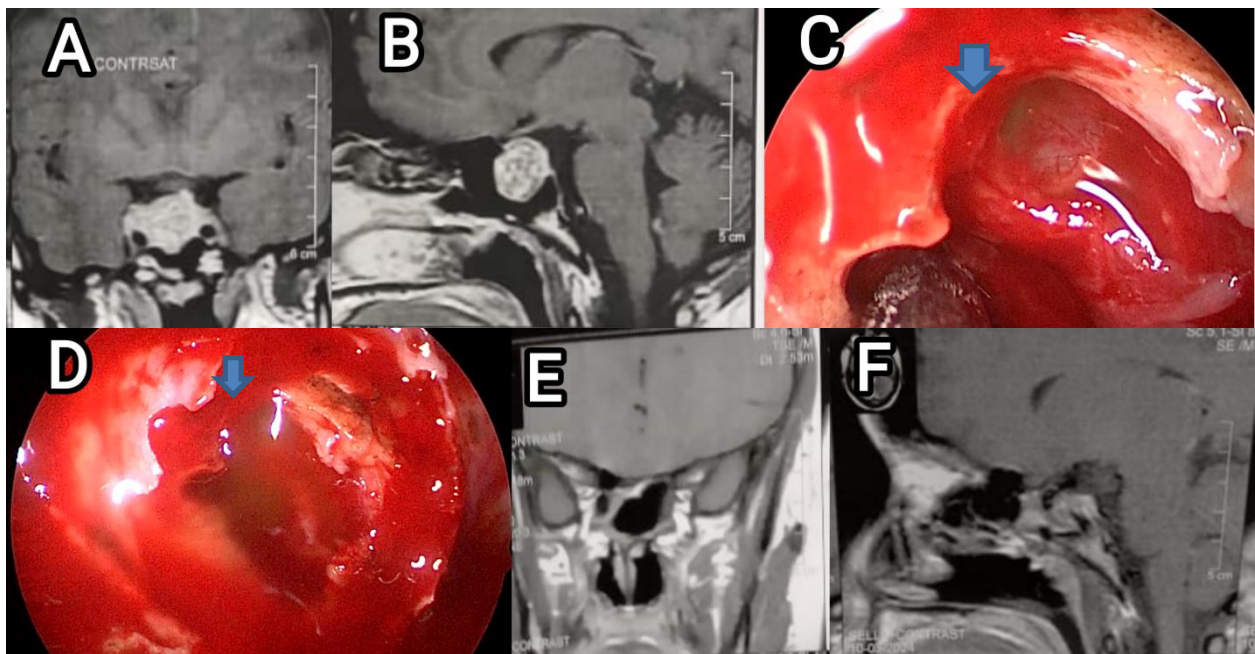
(A) and (B): preoperative MRI sella with contrast, coronal & sagittal views showing hemorrhagic pituitary macroadenoma. (C) and (D): intraoperative CSF leak appeared after fluorescein intrathecal injection and took the green colour of fluorescein. (E) and (F): postoperative MRI sella with contrast showing complete excision of the adenoma.
